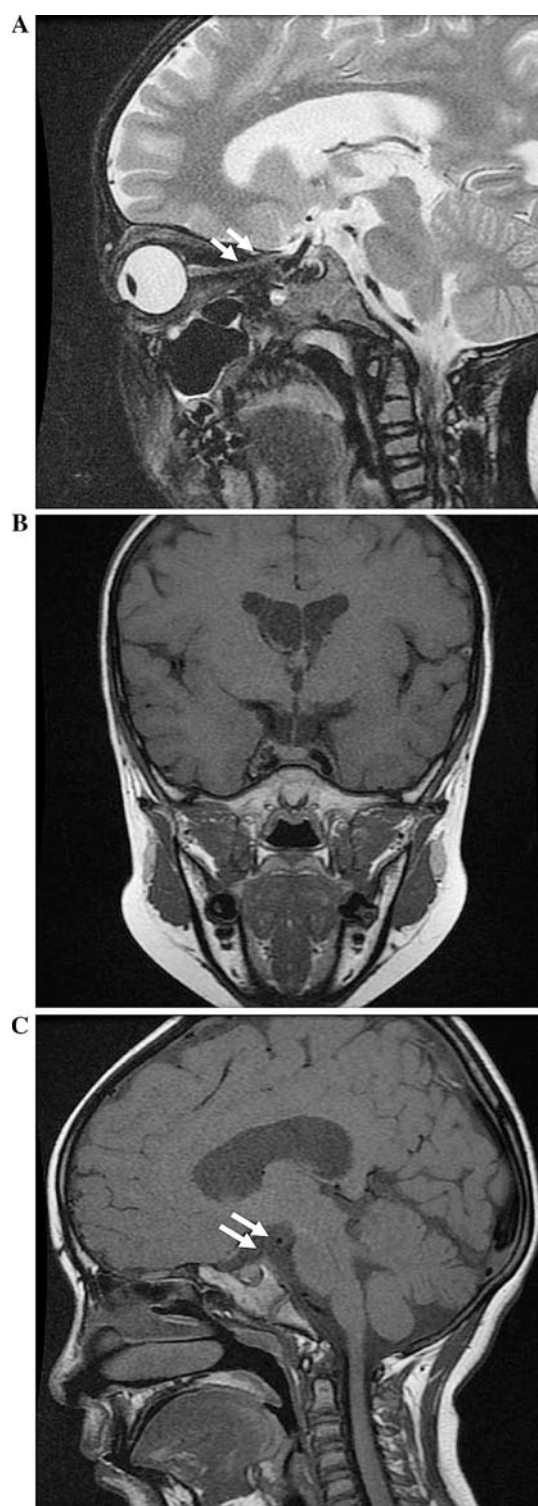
Cranium MR images showed signal-intensity abnormalities in optic radiation on both sides and intracranial optic nerve atrophy (a, arrowheads) and absence of T2-hyperintensity normally recognized in the posterior pituitary lobe (b, c, arrowheads)
